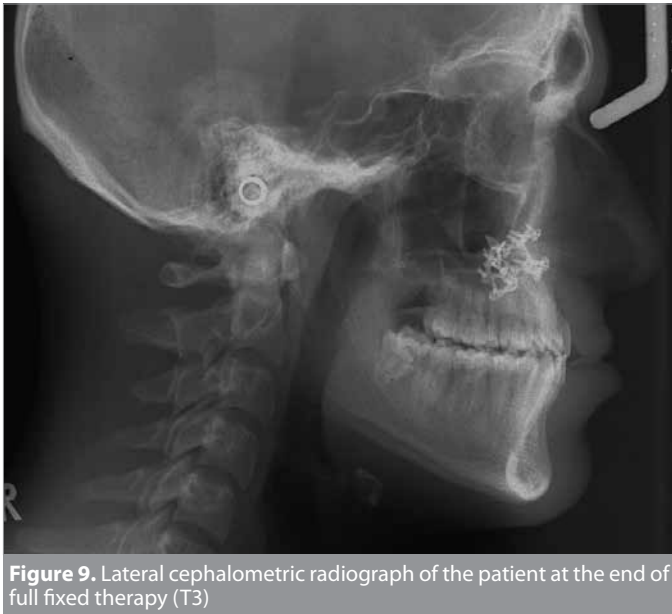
Lateral cephalometric radiograph of the patient at the end of full fixed therapy (T3)
